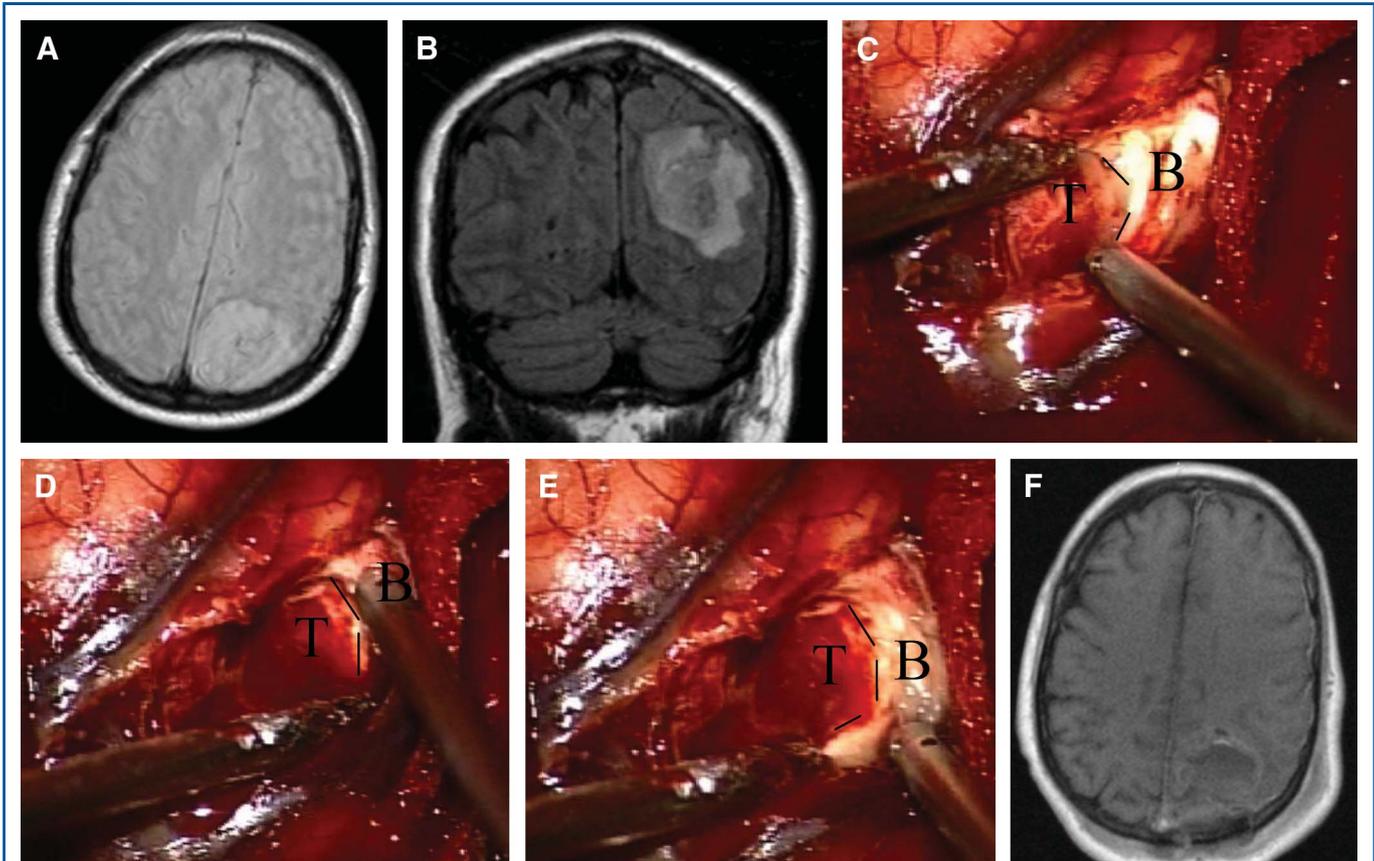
Circular tumor dissection of an anaplastic astrocytoma from the surrounding brain parenchyma with slow continuous movements of the water jet using pressures of 6 bar. Preoperative T1-weighted axial (A) and coronal (B) magnetic resonance imaging (MRI) showing the nongadolinium-enhancing mass lesion in the left occipital lobe. C-E, separation of the tumor from the adjacent brain. The tumor–brain parenchyma border is maintained precisely for exact tumor removal. The suction device is held in the left hand and the water jet nozzle in the right hand. T, tumor; B, brain parenchyma; dotted line, tumor–parenchyma border. F, postoperative T1-weighted axial MRI showing the tumor resection without evidence of remnant tumor mass.
